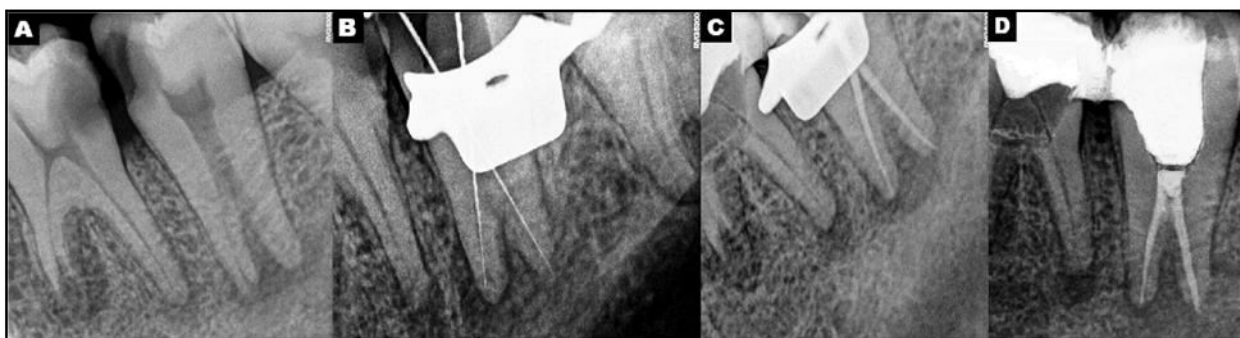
(A) Pre-operative radiograph, (B) Working length, (C) Master cone, (D) Post-operative radiograph.
